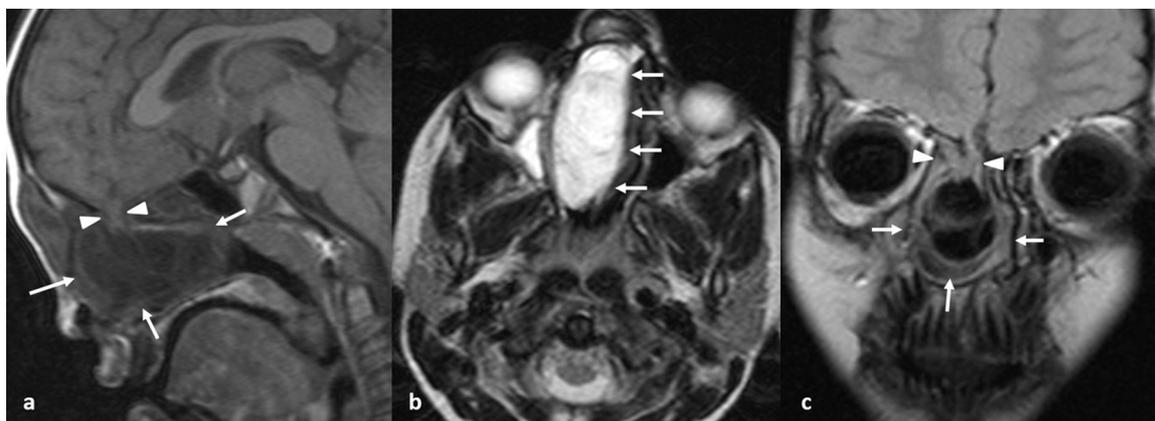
Two-year-old child with intermittent watery discharge from right nostril: a: sagittal T1-weighted MR image demonstrates the hypointense component suggestive of CSF (arrows) and isointense component in right nasal cavity with widening of foramen caecum indicating parenchymal herniation (arrowheads); b: axial T2-weighted MR image shows hyperintense lesion in right nasal cavity indicating fluid component (arrows) with displacement of nasal septum towards left side; c: coronal FLAIR image shows suppression of fluid component in the centre (arrows) with isointense component superiorly indicating herniating parenchyma (arrowheads). [Image courtesy – Dr. Kavinraj Murukesan].
